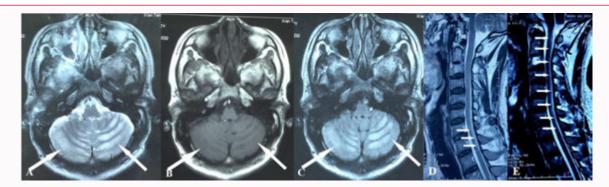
A. T2-weighted imaging (white arrow, tiger striped sign), B. T1-weighted imaging (white arrow, tiger striped sign), C. FLAIR (white arrow, tiger striped sign), D, E. T2-Weighted Imaging (T2WI) showed an hyperintense signal in the posterior column of the cervical spinal cord, lesions progress over time. (D 2016-08-27, E 2016-08-30).
